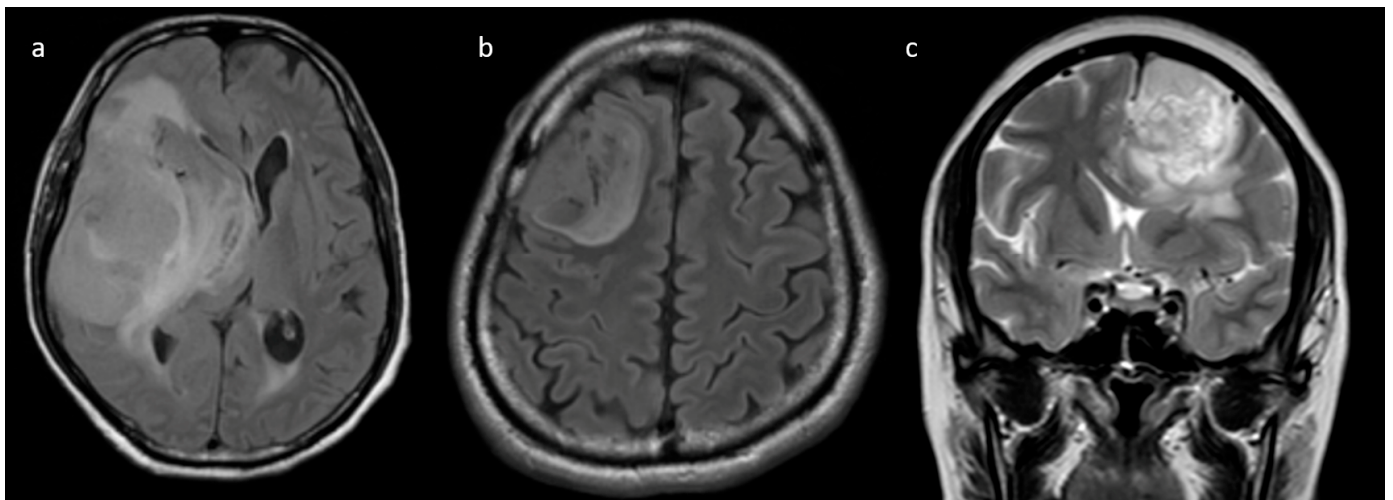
(a–c) Representative axial FLAIR and coronal T2w images show a tumor with a broad base towards the cortex with subcortical involvement.
